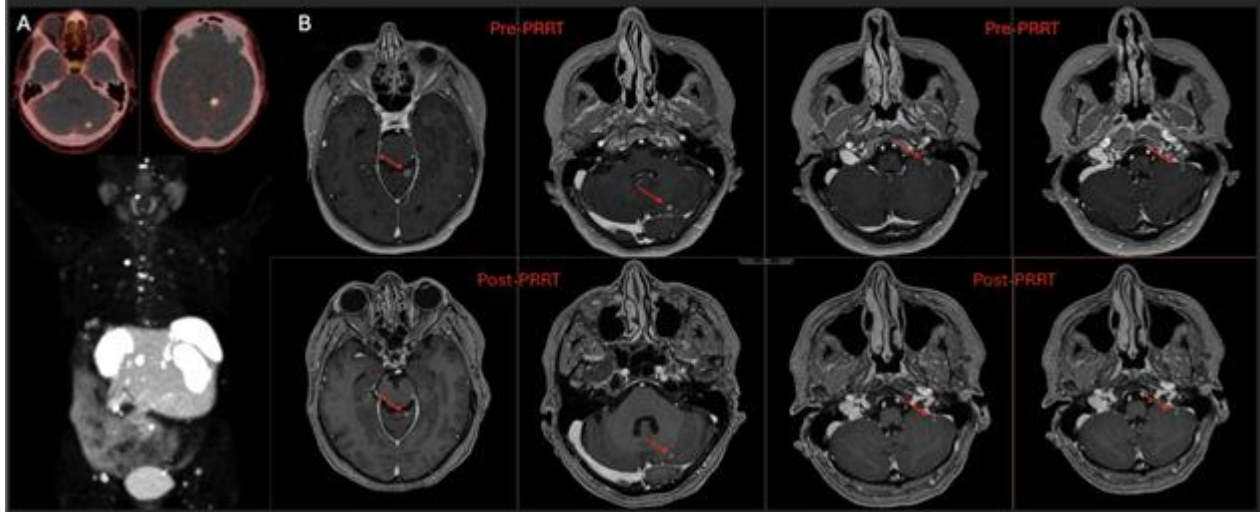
(A) Whole-body  $^{68}\text{Ga}$ -DOTATATE PET/CT axial slices of two intraparenchymal brain metastases and maximum intensity projection showing somatostatin receptor-avid metastatic disease. (B) Representative axial post-contrast T1 MP-RAGE MRI demonstrating interval decrease in size of sub-centimeter cerebellar metastases pre-PRRT versus post-PRRT ( $^{177}\text{Lu}$ -DOTATATE).
